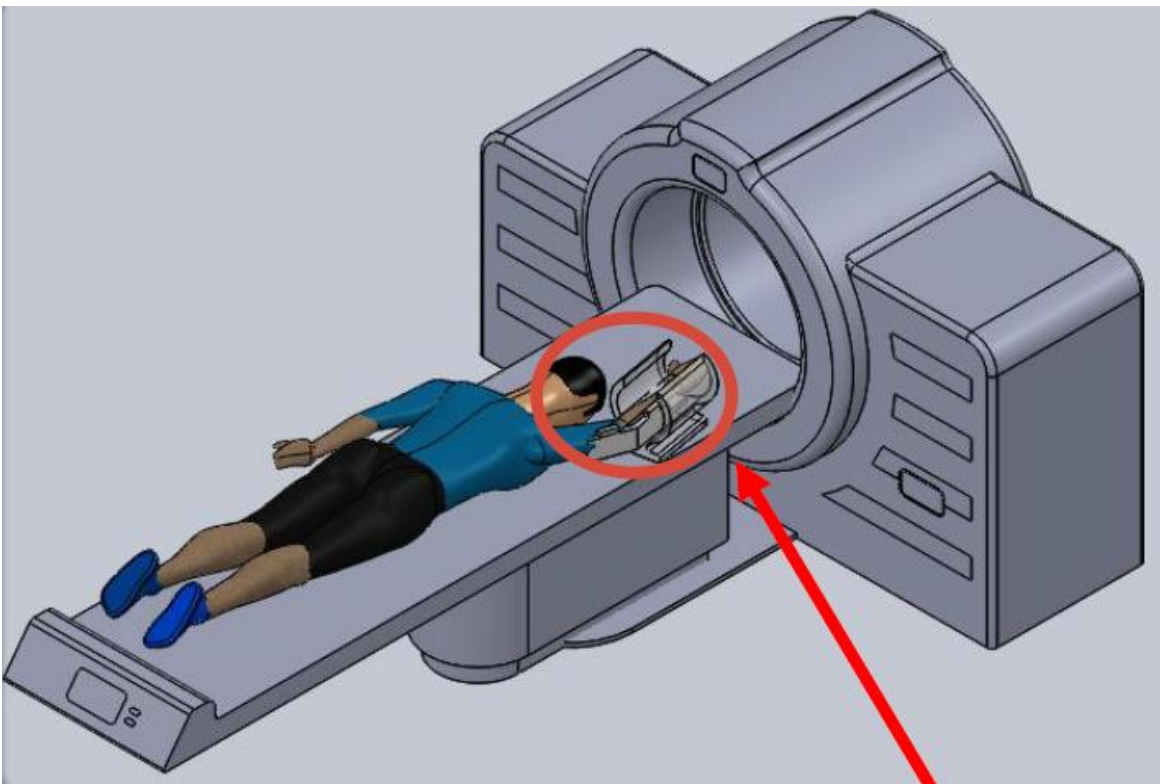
Overview of the final device within the MRI environment.
